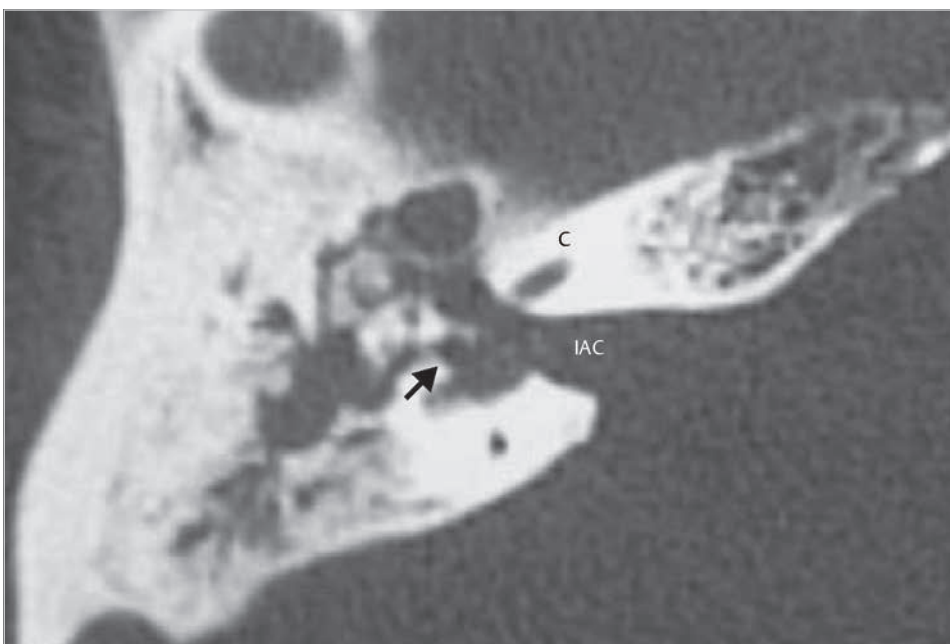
The preoperative axial CT shows extension of the cholesteatoma matrix toward the fundus of the internal auditory canal eroding the labyrinthine segment of the fallopian canal and the bone medially to the ampulla of the superior semicircular canal (arrow). C, cochlea; IAC, internal auditory canal.
